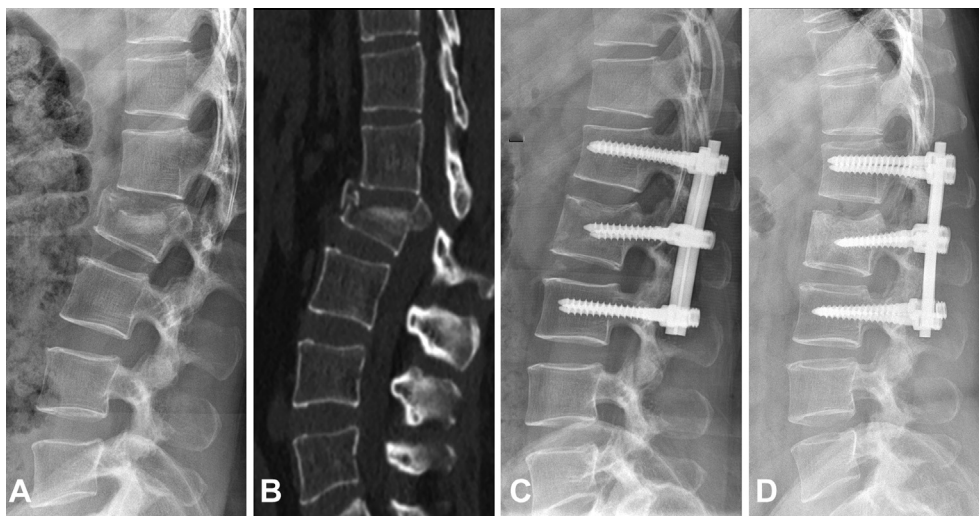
A 49-year-old woman with a L2 burst fracture (AO classification: A3, TLICS: 5). (A and B) The lateral radiograph and sagittal, axial computed tomography images obtained before surgery. (C) The patient was treated by OP PF. (D) Plain radiograph obtained at the 1-year follow-up. TLICS, Thoracolumbar injury classification and severity scores; OP PF, open posterior pedicle fixation.
